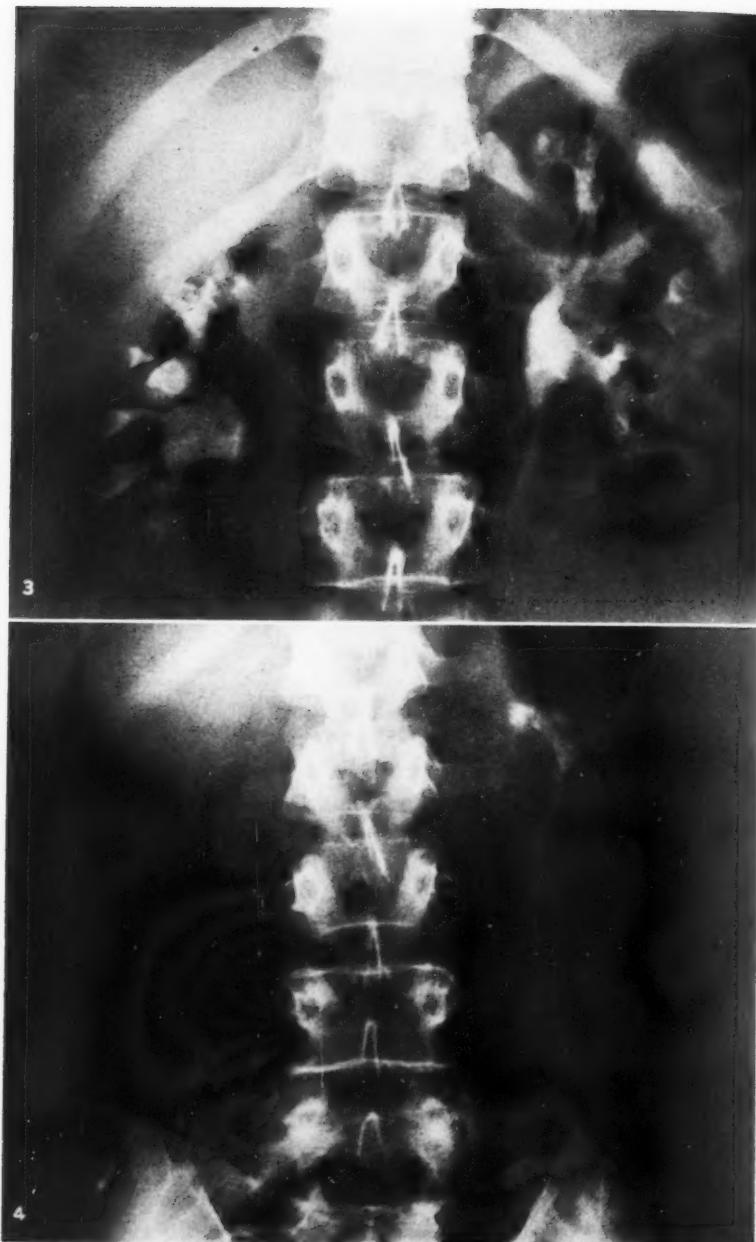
Case I. Roentgenogram following the intravenous injection of 50 per cent Hypaque, demonstrating normal appearing calyceal system and pelvis, with the opaque medium outlining dilated structures (collecting tubules) containing calcific deposits.
